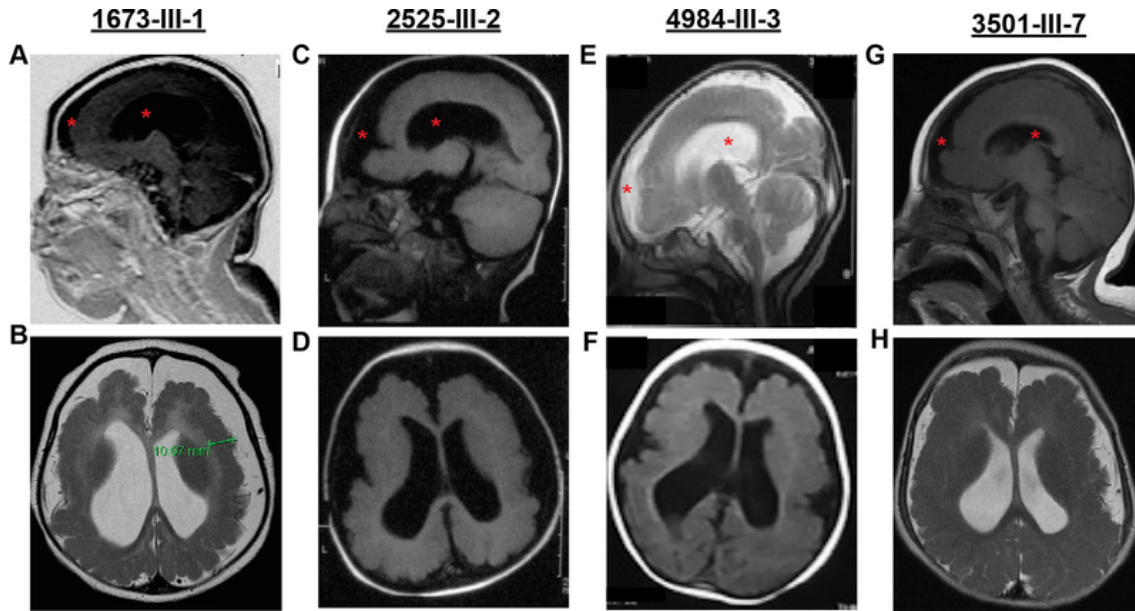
MRIs from affected children display lissencephaly, microcephaly, and brain atrophy. Top row: Midline sagittal MRI. Bottom row: Axial MRI. Subject ID provided at top. All images are T1-weighted except (B, E, H), which are T2 weighted, selected to best demonstrate the main imaging defects. The lack of cortical folding is apparent in both frontal and occipital regions, consistent with lissencephaly. Red asterisk in top row highlights ventriculomegaly and increased extra-axial fluid accumulation, consistent with brain atrophy and microcephaly. Bottom row shows paucity of cortical gyri and thickened gray matter, which was measured at 10.07mm (green bracket) in (B), which is roughly twice the width of normal.
